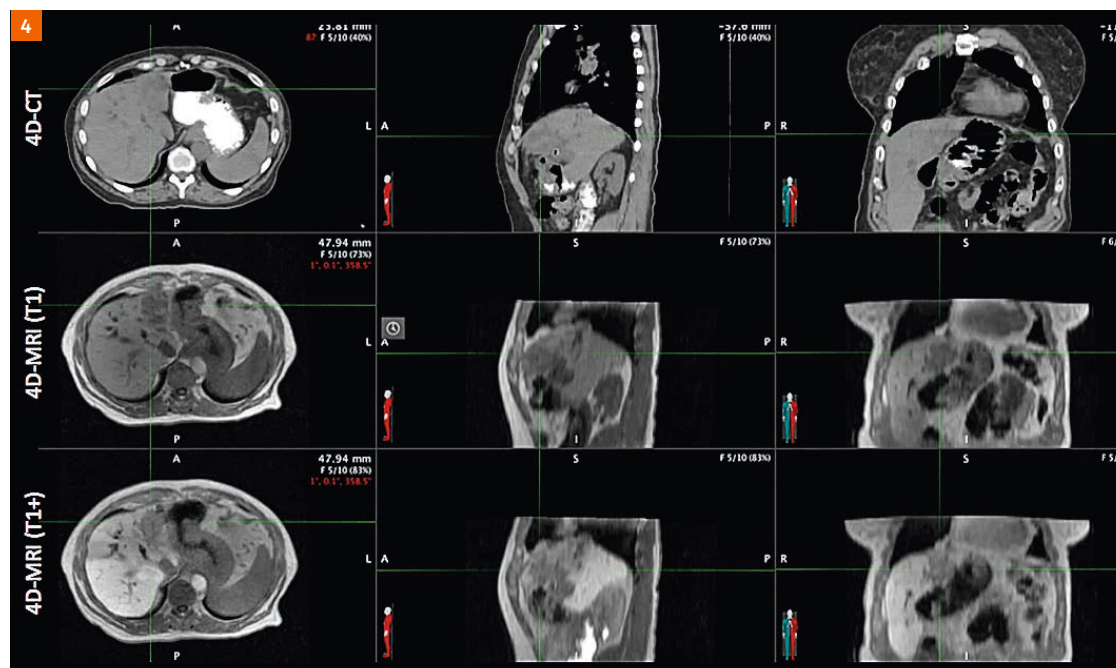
Comparison of 4D-CT (top row) and T1-weighted pre- (middle row) and 20 minute post-Eovist (bottom row) 4D-MR images in a cholangiocarcinoma patient.
